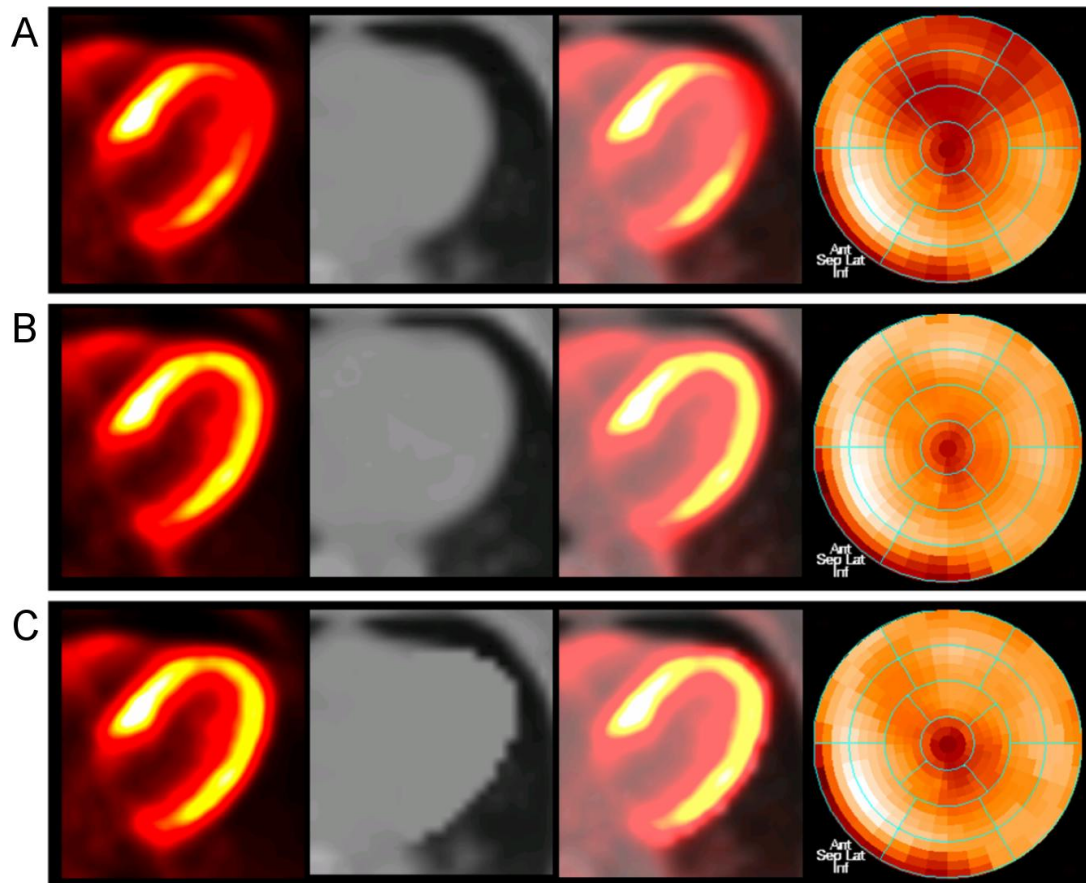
Study with a PET-CT misregistration of 11 millimeters. Columns from left to right: PET, CT, fused PET/CT and polar map. From top to bottom: (A) Original study. (B) Study after manual registration and reconstruction using the coregistered attenuation map. (C) Study after emission-driven correction and reconstruction using the modified attenuation map. Undercorrection for attenuation in the anteroapical and anterolateral segments produced reduced apparent uptake and was assessed as a perfusion defect (24% of the myocardium) after comparison with a normal database. Both correction methods had comparable results, recovering the uptake in these segments and demonstrating that the defect was completely artifactual. Image reprinted by permission of the Society of Nuclear Medicine from [185].
